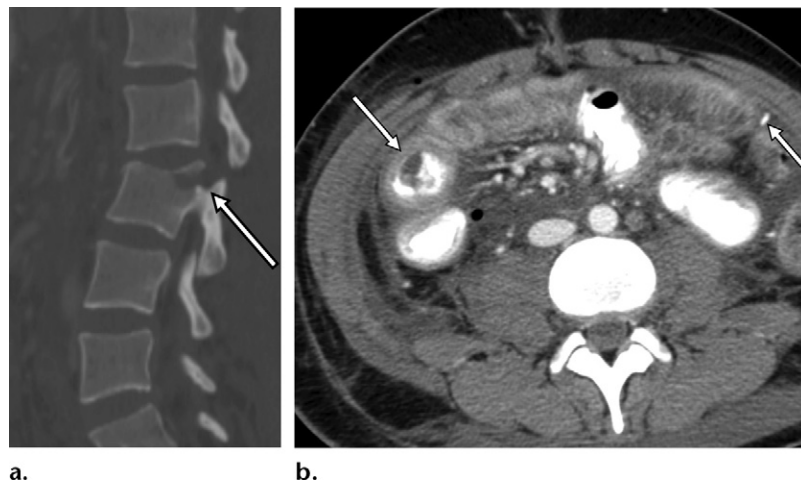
Chance-type fracture in a 25-year-old woman with abdominal and back pain after a motor vehicle collision. (a) Sagittal multidetector CT image shows a hyperflexion injury of the lumbar spine, with an L2 vertebra fracture and distraction of the posterior elements (arrow), the so-called Chance fracture. (b) Axial CT image of the abdomen shows bowel wall edema and mucosal hyperenhancement (arrows). At laparotomy, devascularized ischemic bowel was encountered, a finding that required right hemicolectomy and partial small-bowel resection.
